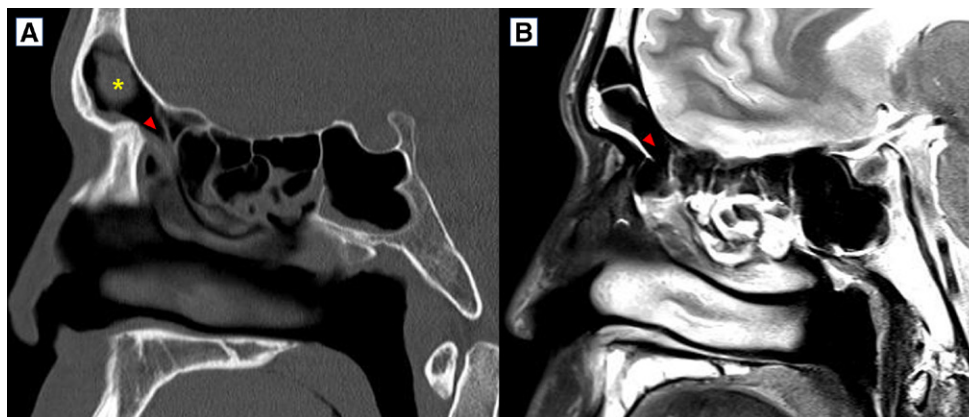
Changes in the frontal sinus outflow tract patency following AR treatment. A) Upon initial visit, the patient's left frontal sinus outflow tract is obliterated with mucosa edema/swelling (red arrowhead), thus causing a frontal sinus barotrauma and submucosal hemorrhage (asterisk). B) On 1-yr MR image, with the appropriate management of the AR, the frontal sinus outflow tract mucosal edema was eliminated (red arrowhead), thus making the outflow tract patent and enabling air passage for pressure equalization.
